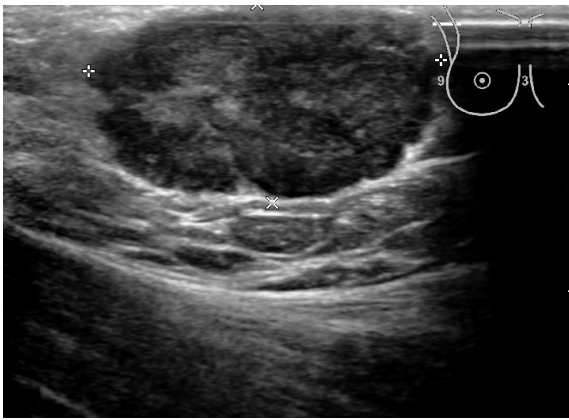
Ultrasound examination showed a 31 mm × 17 mm mass in the right axillary accessory breast.
